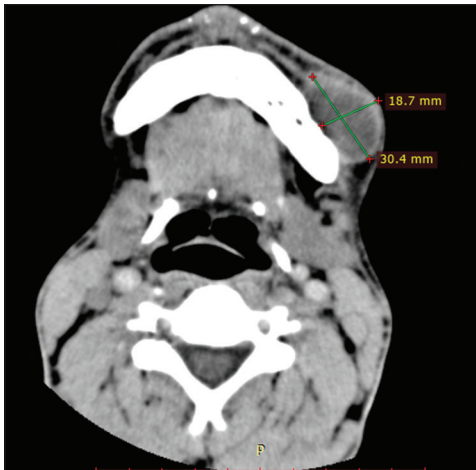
Computed tomography showed a well-defined encapsulated fusiform soft tissue mass with a density of 20–30 HU, minimal appreciable enhancement, causing scalloping of the adjacent bone and thinning of the buccal cortex
